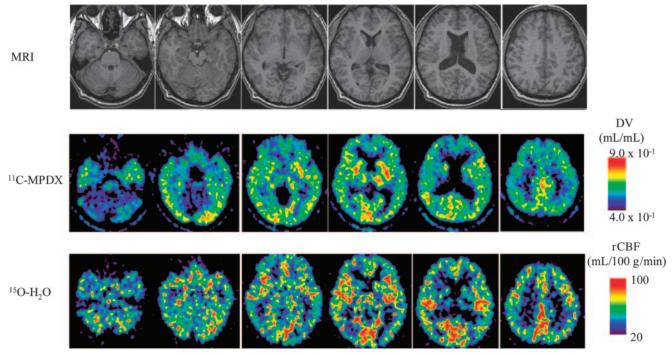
Brain MRI and PET parametric images in typical case. (Top) MRI. (Middle) Distribution image (DV) of ¹¹C-MPDX. (Bottom) rCBF with ¹⁵O-H₂O. DV of ¹¹C-MPDX was low in cerebellum and high in striatum and thalamus, where rCBF was relatively lower.
